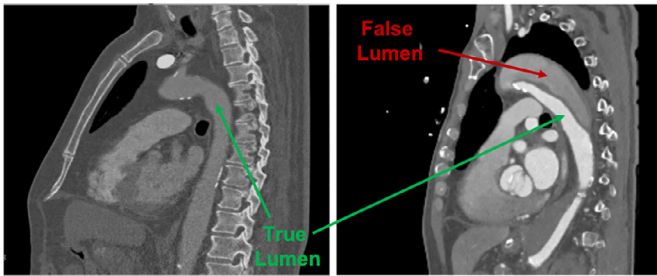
Computed tomography angiography of a healthy subject (left), where only one lumen is visible in the aorta; an aortic dissection case, where the false and true lumina are clearly distinguishable (right).
